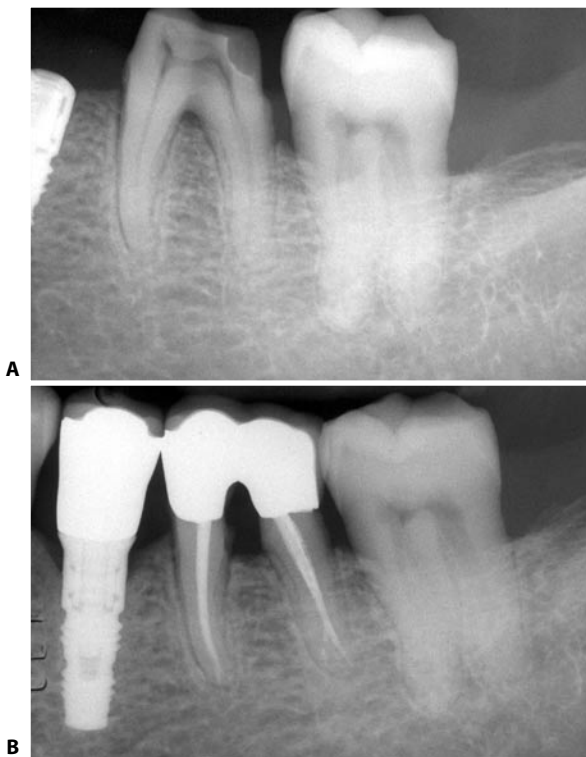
A. Preoperative radiograph. The lower first molar has a furcation involvement of periodontal origin and needs to be endodontically treated in order to be bicuspidized. B. 16 month recall.
